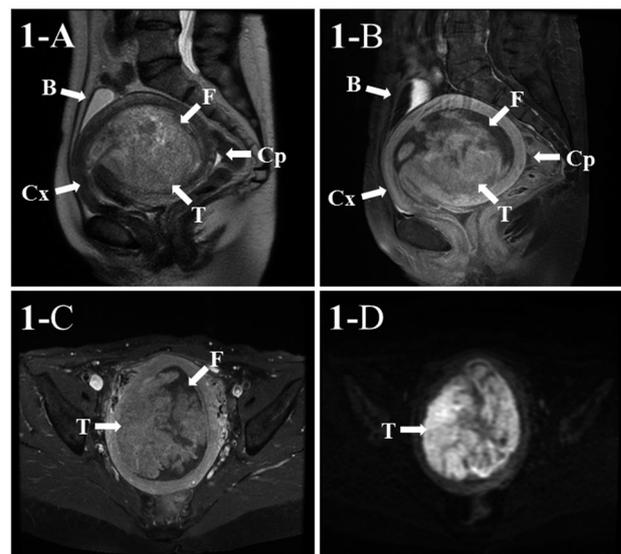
Findings of preoperative magnetic resonance imaging. (1-A: sagittal T2-weighted image, 1-B: sagittal contrast-enhanced T1-weighted image, 1-C: transverse contrast-enhanced T1-weighted image, and 1-D: transverse diffusion-weighted image). Magnetic resonance imaging clearly reveals severely retroverted uterine corpus (Cp) fully-filled with a papillary growing tumor (T) accompanied with a heterogeneous fluid collection (F) suggestive of pyometra, an anteriorly displaced and elongated uterine cervix (Cx), and a markedly upward extended bladder (B). The strong enhancement and the higher ADC values of the tumor indicate the possibility of uterine malignancy with tumor necrosis.
